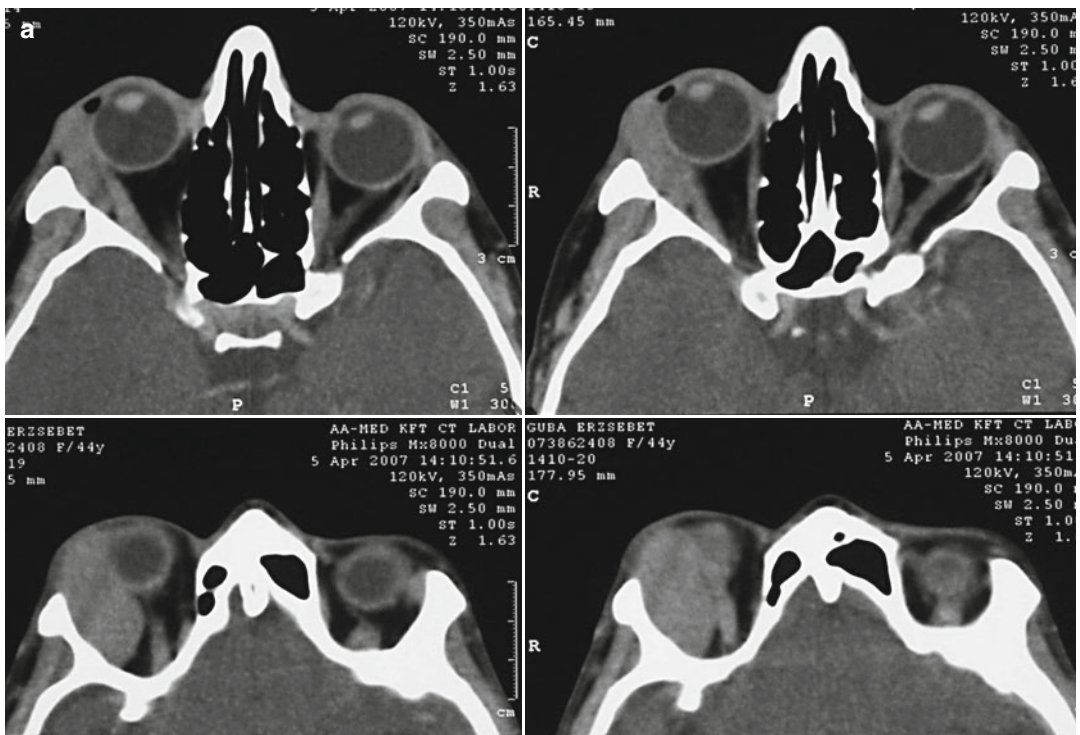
Malignant lymphoma in the region of the right lacrimal gland (a) CT images. (b) Facial photography. (c) Swollen eyelid lobe
